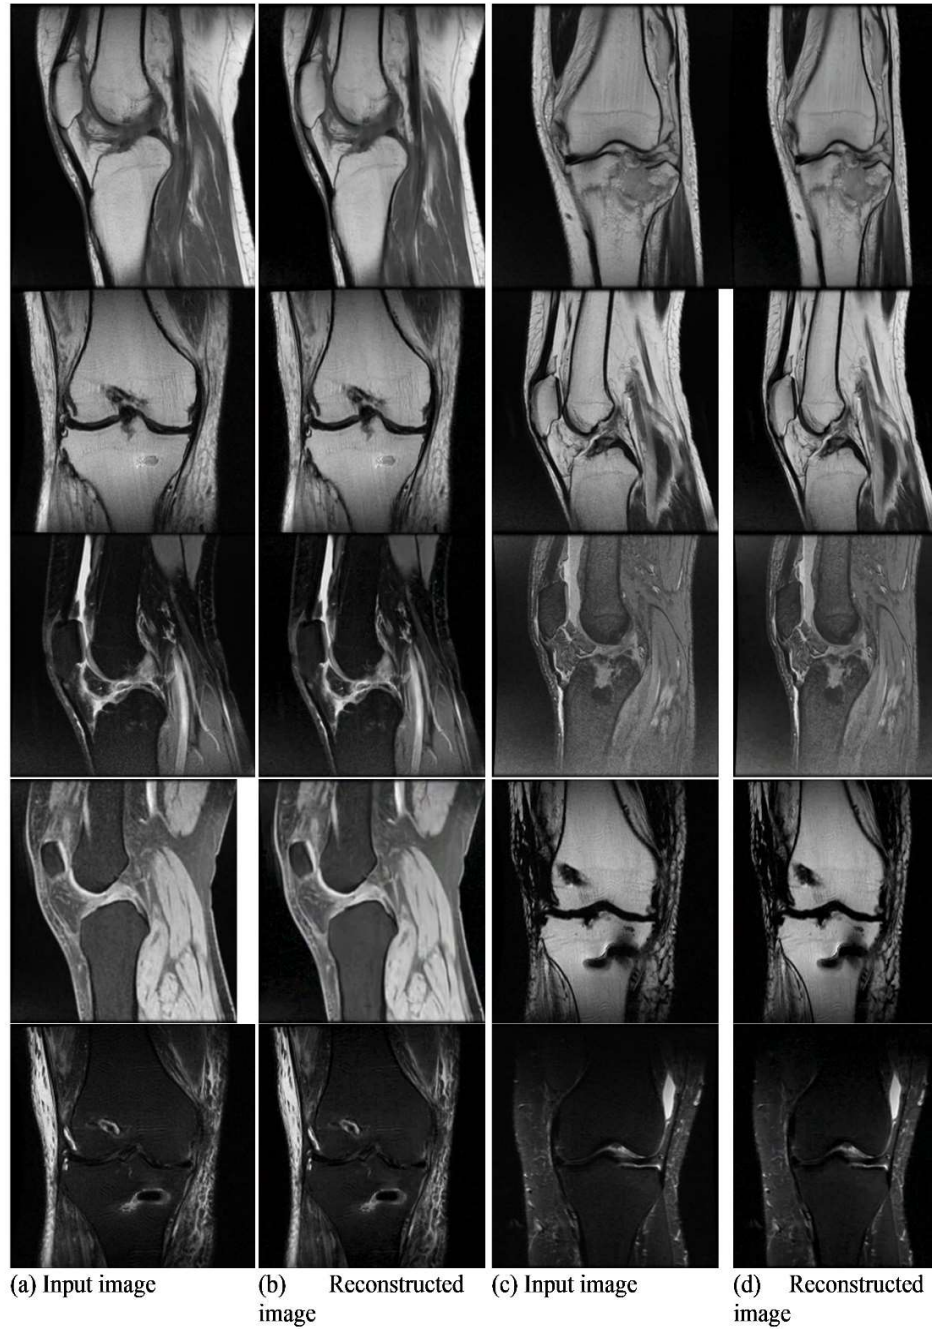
Denoised Knee MR images achieved with SANR\_CNN.
